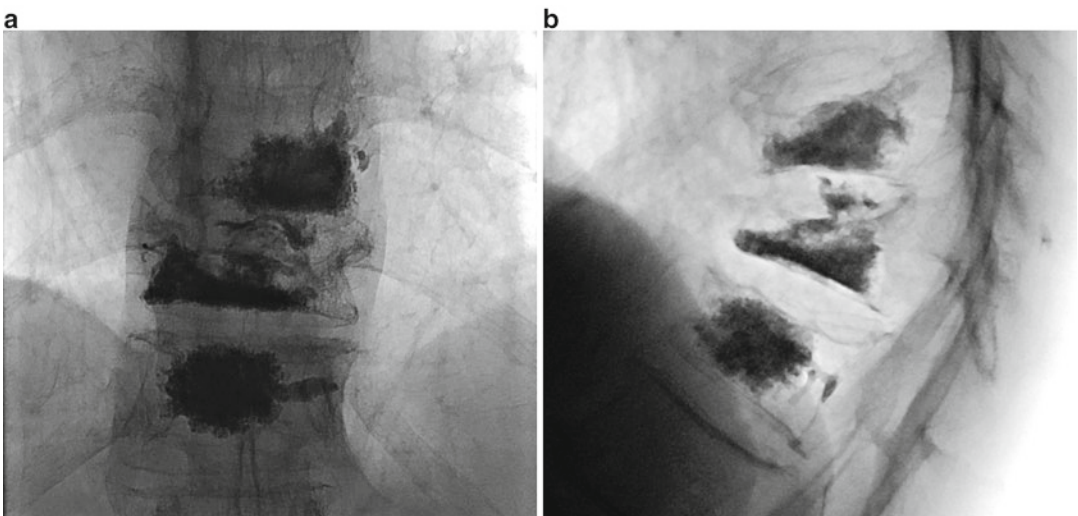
(a) Showing postoperative AP radiographs and (b) sagittal radiographs post-augmentation. It should be noted that with vertebroplasty, end plate reduction and deformity correction are no different than preoperative imaging
